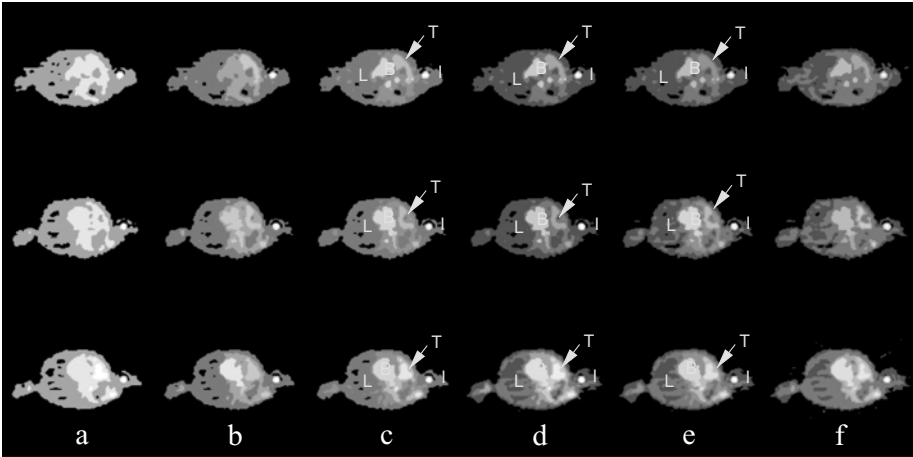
Tissue segmentation of the dynamic lung FDG-PET data from Patient 3 in three selected slices: 4 (top row), 19 (middle row), and 24 (bottom row) with different number of clusters. (a) $k = 4$, (b) $k = 7$, (c) $k = 8$, (d) $k = 9$, (e) $k = 10$, and (f) $k = 12$. (I = injection site; B = blood pool; L = lung; T = tumor).
